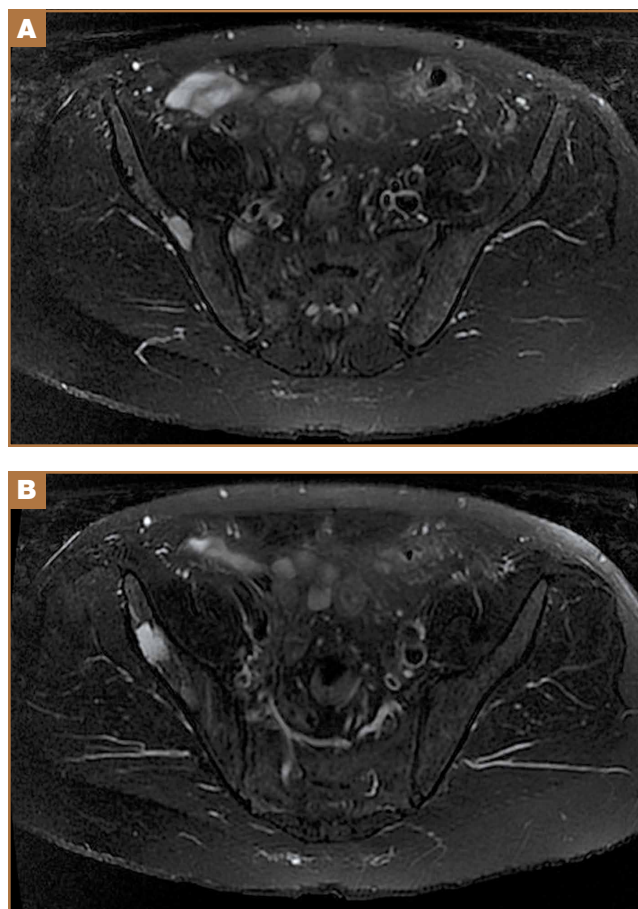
(A, B) Axial T2-weighted magnetic resonance imaging of pelvis.
